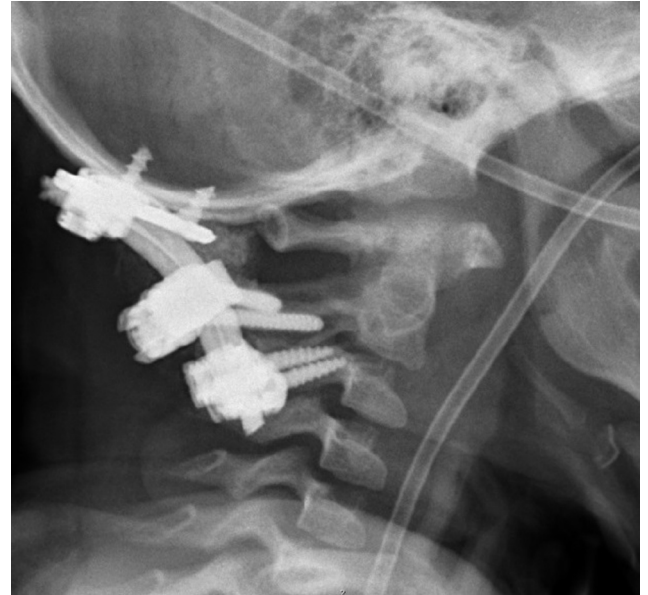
Postoperative radiographs showing stabilization and fusion from occiput to C3.
